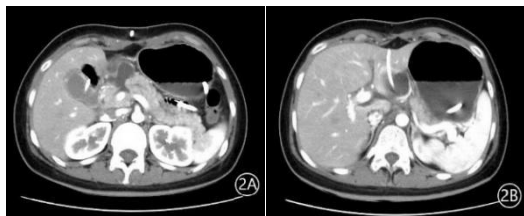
Abdominal CT showing A. localized rupture of the pancreatic head/neck; and B. a pseudocyst, drained with a catheter
